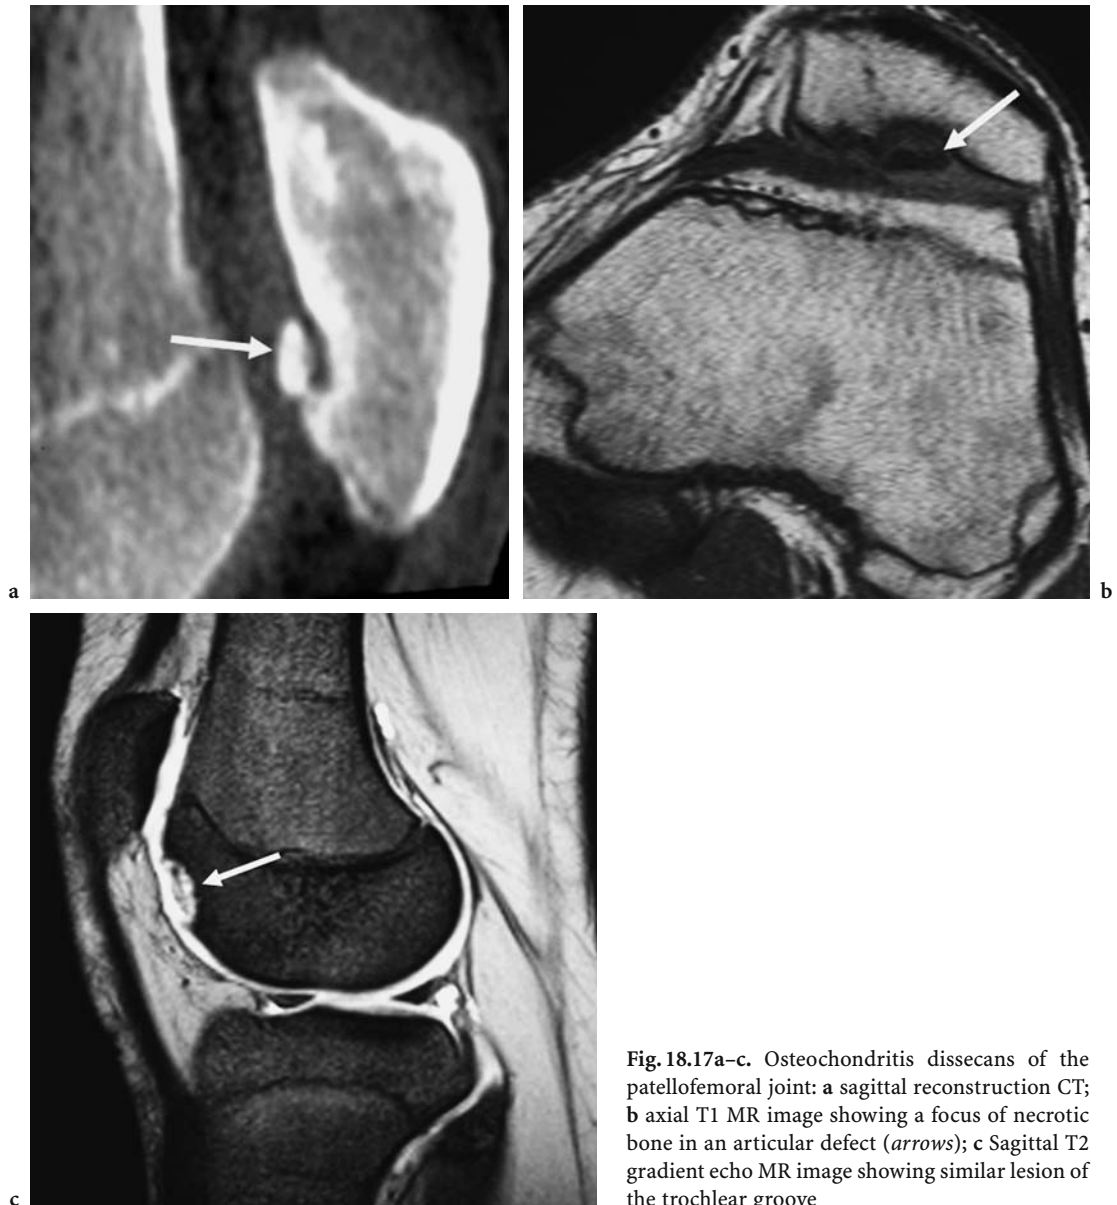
Osteochondritis dissecans of the patellofemoral joint: a sagittal reconstruction CT; b axial T1 MR image showing a focus of necrotic bone in an articular defect (arrows); c Sagittal T2 gradient echo MR image showing similar lesion of the trochlear groove
